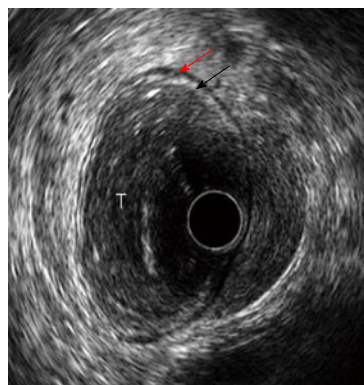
Stage T1 rectal cancer: miniprobe ultrasonographic view. Endoscopic ultrasound with radial miniprobe (12 MHz), showing a small tumor located within the mucosa and superficial submucosal layers, with preservation of the outer layers of the rectal wall. T: Tumor; Red arrow: Muscularis propria layer; Black arrow: Submucosa layer.
